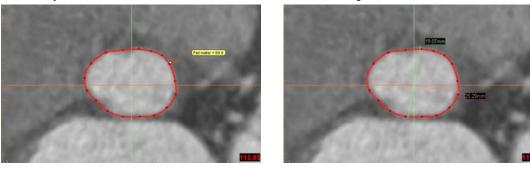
Figure CTA-4: Example of perimeter measurement (left) and major and minor diameter measurements (right).
